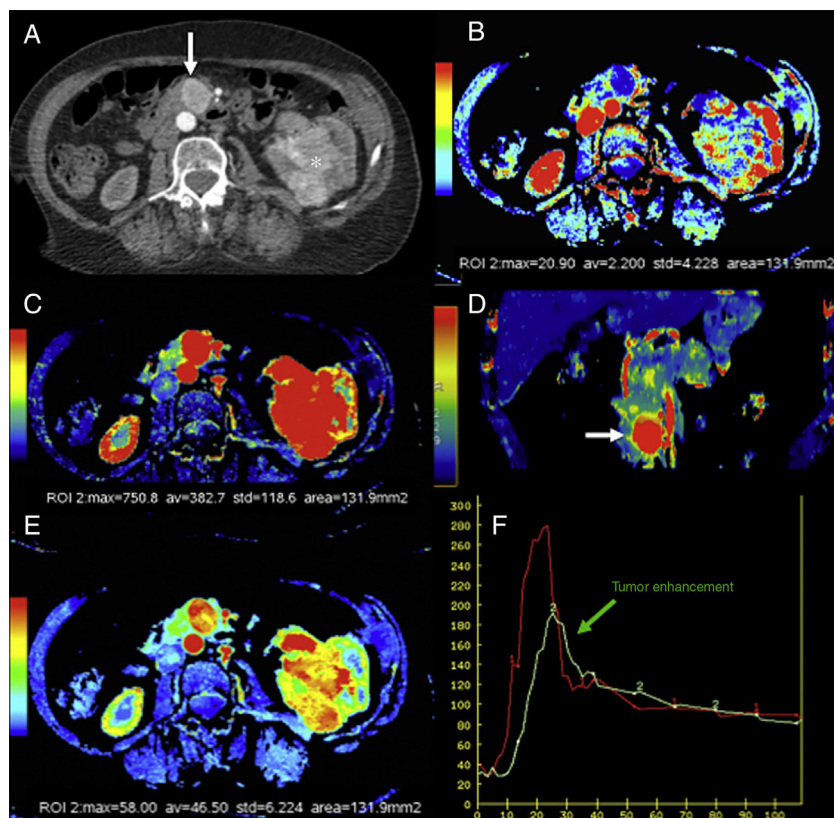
Computed tomography (CT) scan with perfusion in a patient with clear cell carcinoma in left kidney and metastasis in the pancreatic uncinate (arrows). CT scan with contrast in the arterial phase (A), parametric maps in the axial plane of patency (B) of blood flow in the axial (C) and coronal (D) planes and of blood volume (E) and uptake curves of aorta and tumor (F). The color-coded maps show high values of blood flow and volume and low values of patency in the pancreatic metastatic lesion compared to a normal pancreas. The imaging time-curve-type analysis shows an enhanced pancreatic metastasis (green curve) with a similar morphology to that of the aorta (red curve).
